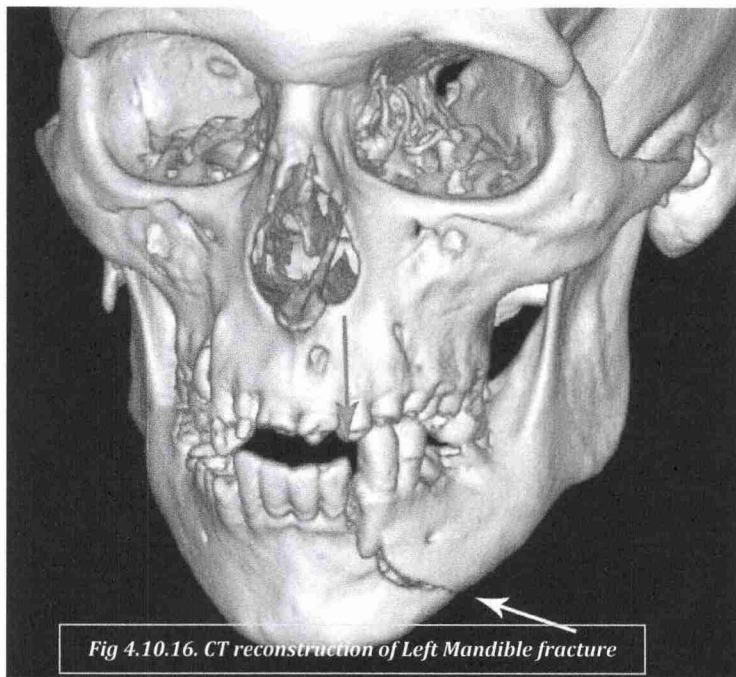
CT reconstruction of Left Mandible fracture
